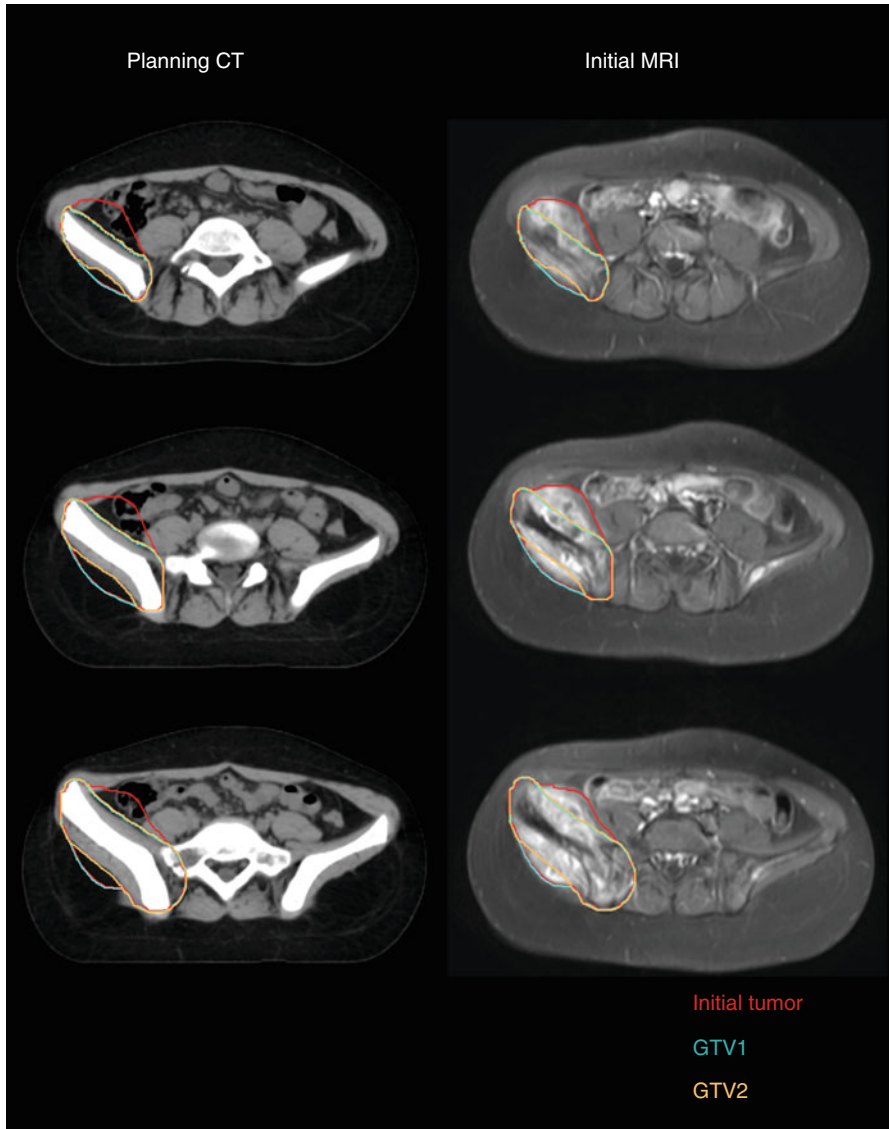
A patient with Ewing's sarcoma involving the pelvis. The initial tumor (as defined by the MRI), GTV1, and GTV2 are shown on the planning CT and initial MRI. For clarity, CTV's are not shown but are GTV + 1 cm
